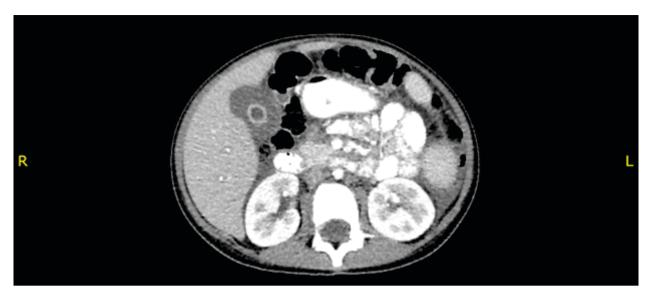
CT scan showing hepatomegaly with a homogenous parenchyma and no visible focal lesions. The gallbladder is correctly positioned, moderately contracted, with a markedly edematous wall measuring 3mm in diameter. Prominent intrahepatic bile ducts and periportal edema are also observed. The common bile duct is not dilated
